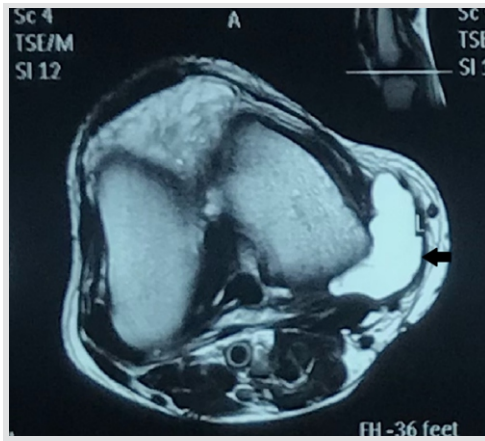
An axial slice T2-weighted MR image shows a meniscal cyst (Black arrow), demonstrated by the hyperintense signal adjacent to the meniscus.
